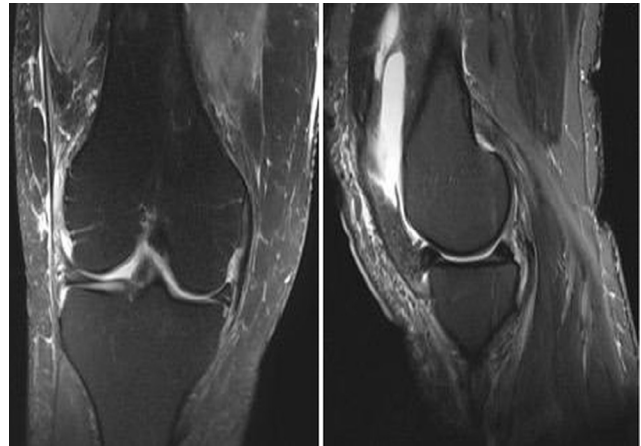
(a) Coronal and (b) sagittal preoperative magnetic resonance images of the right knee showing a degenerative medial meniscal tear, with no evidence of osteonecrosis.
